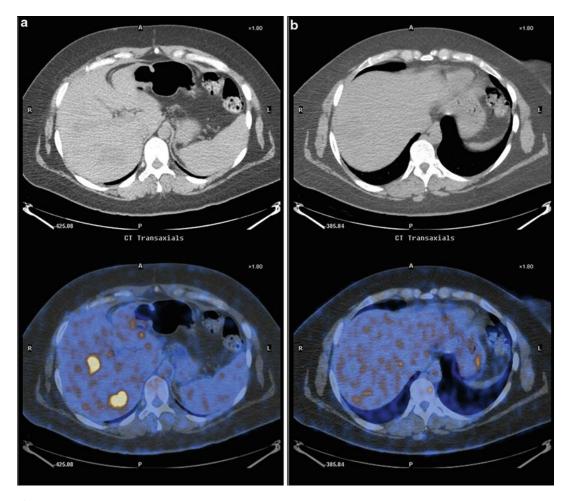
This is a patient with multiple hepatic metastases with colon cancer. She was previously treated with RFA in the right lobe seen as a low-density lesion (b, *upper*) and the PET/CT (b, *lower*) showing a circular
